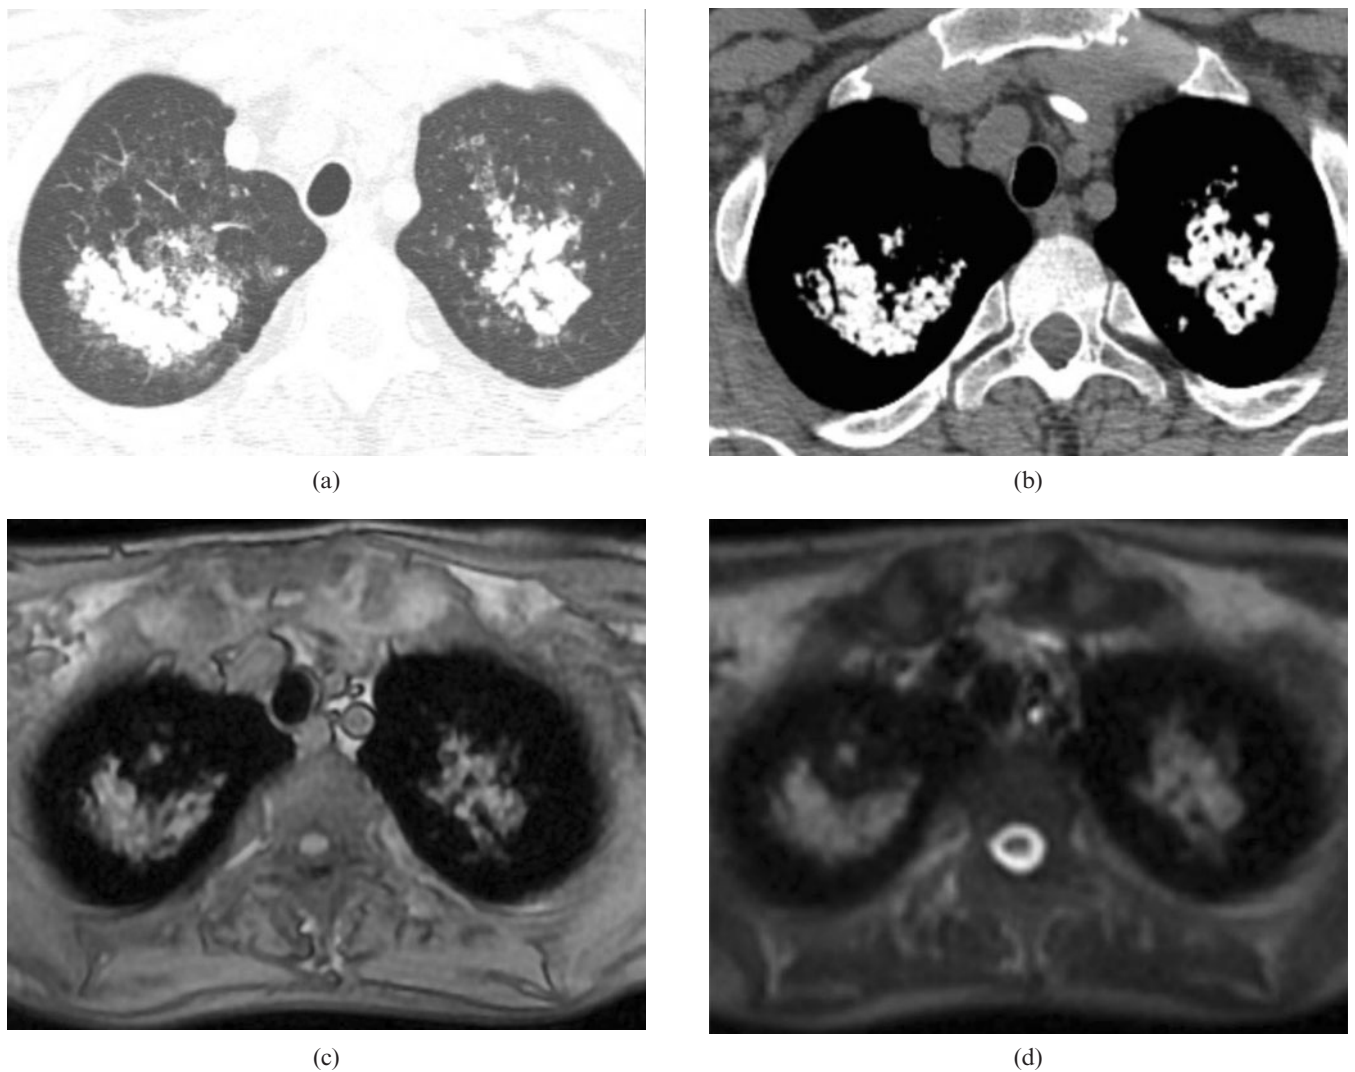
Axial CT scan with (a) lung and (b) mediastinal windows showing consolidation areas with calcification in the upper lobes. (c) Axial T_1 weighted images demonstrated higher signal intensity for the lesions than for skeletal muscle. (d) Axial T_2 weighted imaging showing that the lesions presented with hypersignal.
